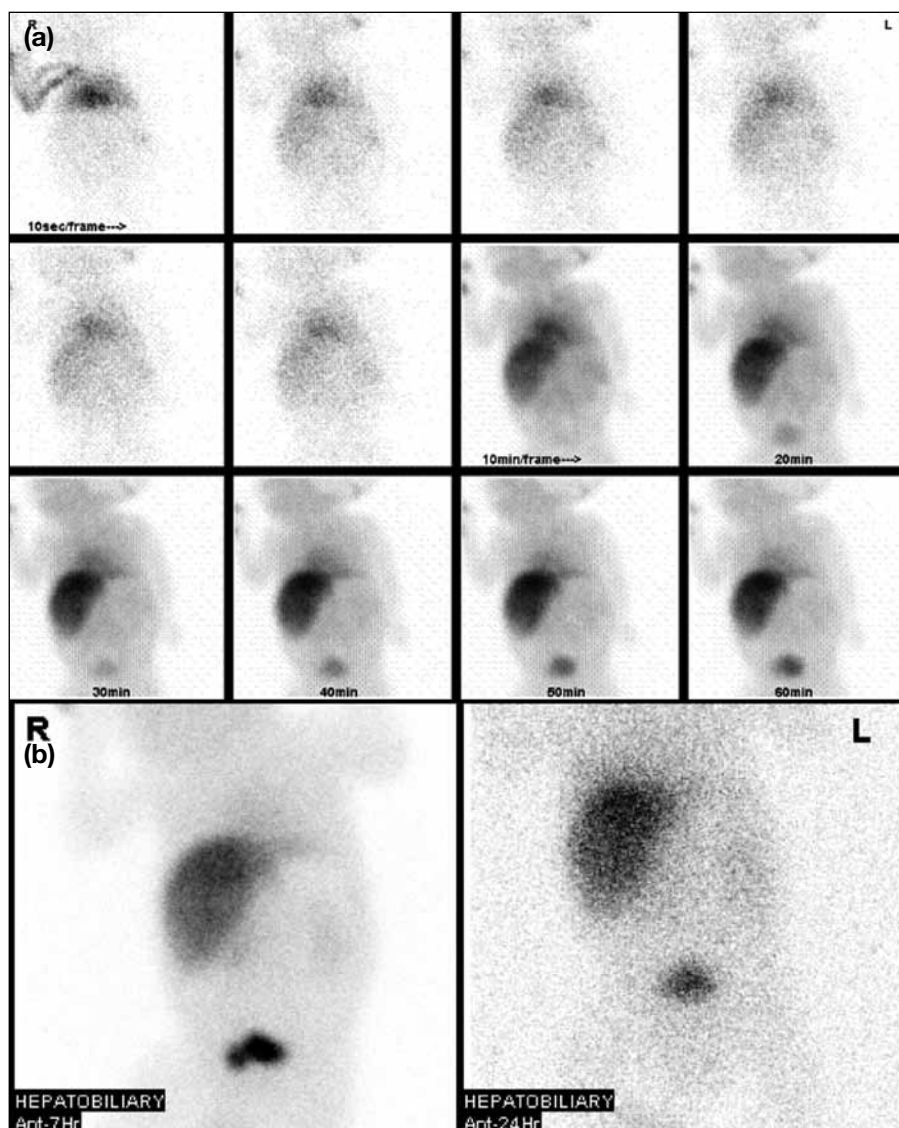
A hepatobiliary scintigraphy with absence of radiotracer in gallbladder or small bowel by (a) 60 minutes, and (b) 7 and 24 hours. This was a false-positive study as proven with repeat scintigraphy shown in Figure 5.
